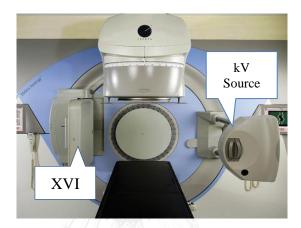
2 The Elekta Synergy X-Ray Volume Imaging (XVI)
